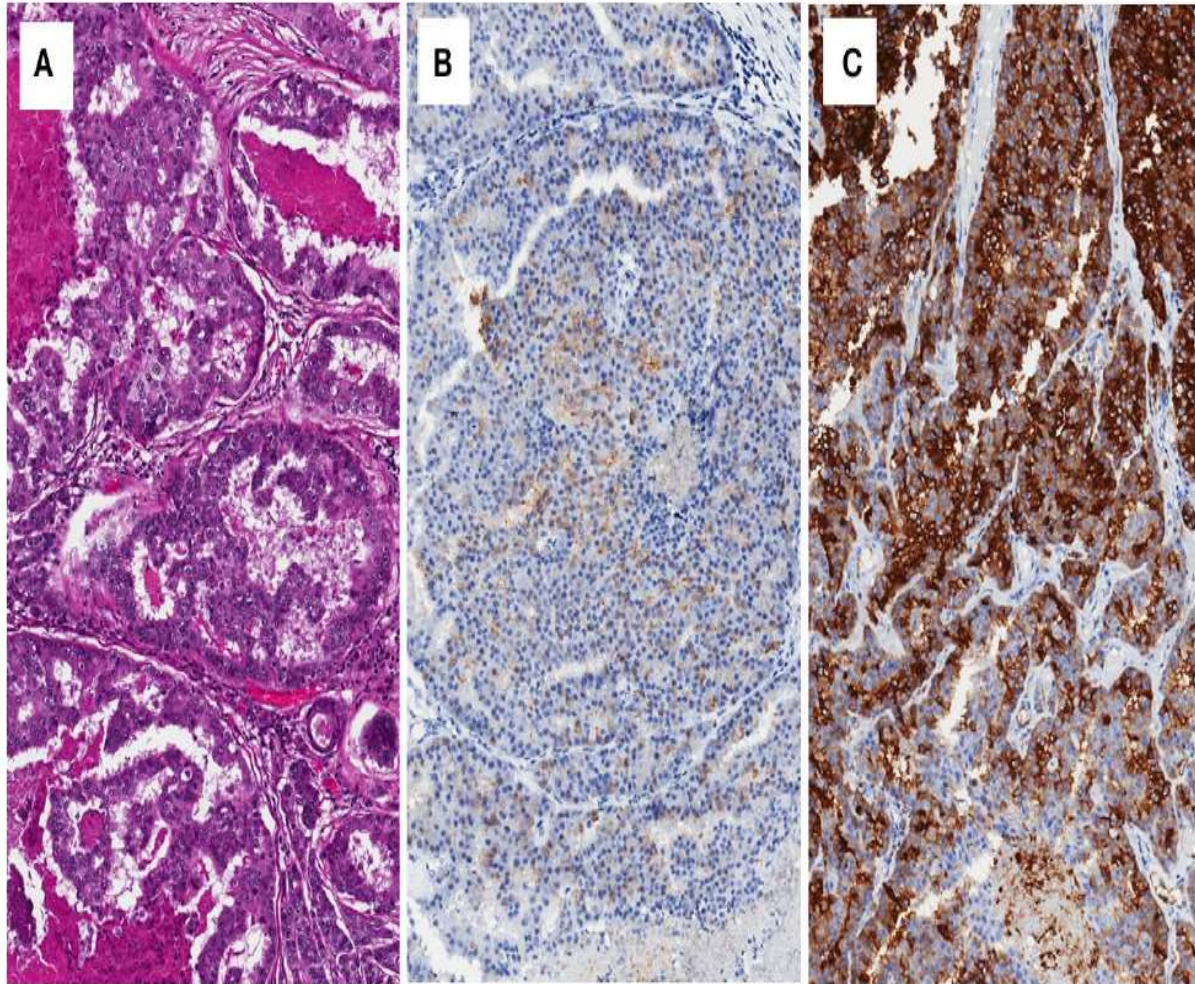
Brain metastasis of prostate cancer with cribriform pattern (A), showing low expression of PSA (B), and intense expression of PSMA (C).
